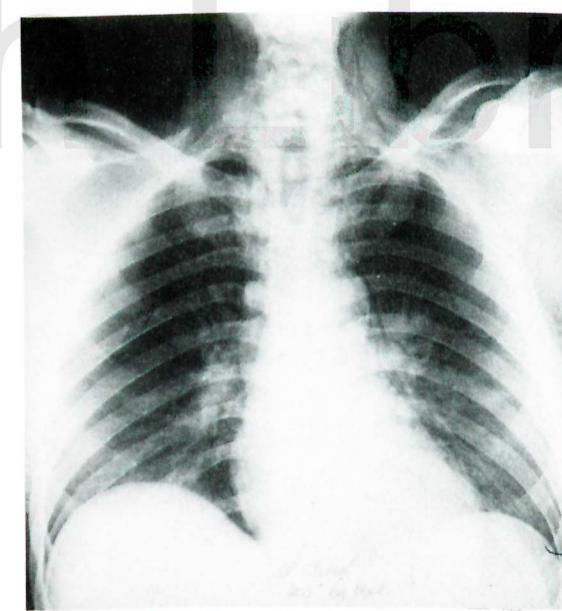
Chest X-ray in a patient who developed perforation of the oesophagus, mediastinitis and surgical emphysema
